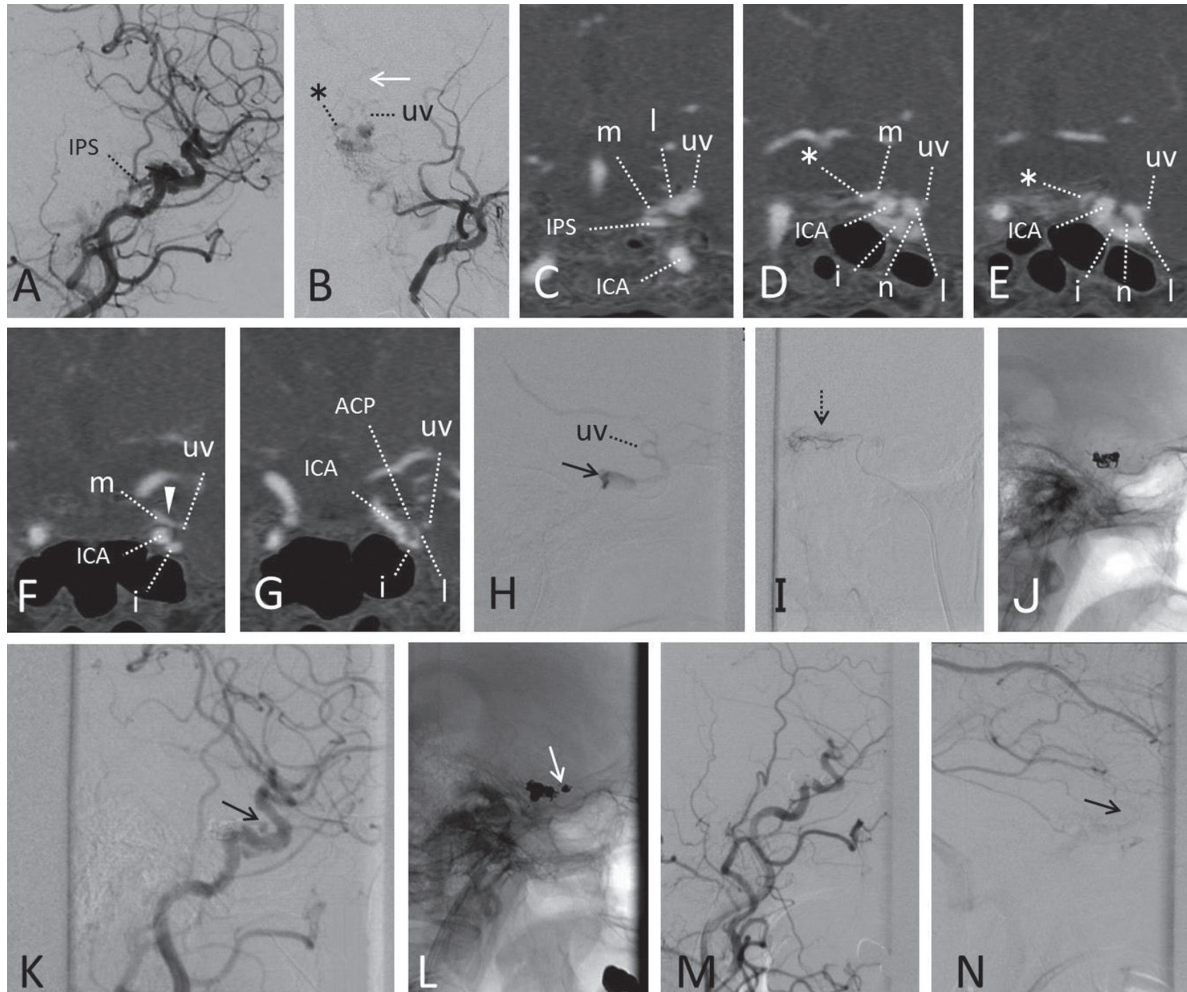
Cavernous dural arteriovenous fistula. A 62-year-old female presented with left abducens nerve palsy. A: Left carotid angiogram (lateral view) showed a dural arteriovenous fistula on the left cavernous sinus (CS) draining posteriorly into the inferior petrosal sinus (IPS). B: Left external carotid angiogram (A-P view) showed fine feeding arteries converging into the medial part (*asterisk*) of the CS, and reflux into the basal vein of Rosenthal (*white arrow*) through the uncal vein (uv). C–G: Preoperative coronal bone-subtraction computed tomography angiograms, from posterior (C) to anterior (G). C: The cross-section at the level of the petrous apex showed the left IPS connected to posterior parts of the medial (m) and the lateral (l) venous axes. The uv emptied into the lateral venous axis. D, E: A small venous pouch (*asterisks*) in the dorsum sellae connected to the medial venous axis (m) was considered to be the fistulous portion. The lateral venous axis (l) connected to the intermediate venous axis (i) crossing beneath the cranial nerves (n). F, G: The intermediate venous axis (i) connected to the anterior part of the medial venous axis (m) through the anterior part of the lateral venous axis (l) and the venous channel (*arrowhead*) beyond the ICA near the anterior clinoid process (ACP). Thus, before the operation, two access routes to the medial venous axis where the fistulous compartment might exist could be identified, the one was from behind directly through the IPS, and the other is through the lateral and intermediate venous axis, and the venous channel beyond the ICA. H: Venogram (lateral view) during the transvenous coil embolization through the IPS showed the lateral venous axis (*arrow*) with a connection to the uv. This lateral venous axis was secured with the one microcatheter. I: Another catheter was introduced into the fistulous compartment situated in the posteromedial part of the CS from the posterior aspect of the medial venous axis, confirming the retrograde opacifying of the feeding arteries (*dotted arrow*) with the venogram (A-P view). J: The fistulous compartment with the posterior part of the medial venous axis was embolized. K: Left carotid angiogram showed a faint shunt flow remained (*arrow*) in the anterior part of the medial venous axis. L: The microcatheter was navigated into this anterior part of the medial venous axis through the intermediate and lateral venous axes, and the venous channel beyond the ICA, and embolization was added (*white arrow*). M: Complete obliteration was achieved without embolizing the intermediate and lateral venous axes. N: The antegrade venous flow of the uv (*arrow*) into the IPS through the lateral venous axis was preserved. A-P: anteroposterior, ICA: internal carotid artery.
